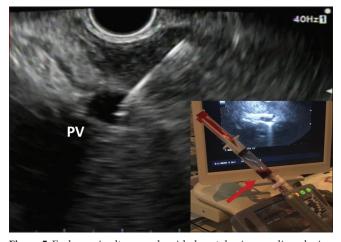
Endoscopic ultrasound-guided portal vein sampling, during the initial Endoscopic ultrasound fine needle aspiration for the pancreatic mass, as a novel "molecular staging approach" for patients with pancreatic ductal adenocarcinoma
